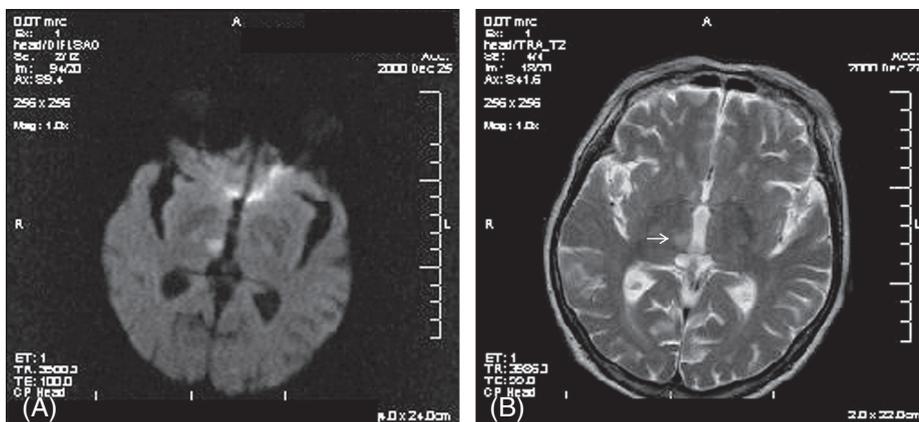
A right-sided paramedian infarct shown by diffusion weighted MRI during the acute phase (A) and, 2 days later, by T2-weighted MRI (B).
